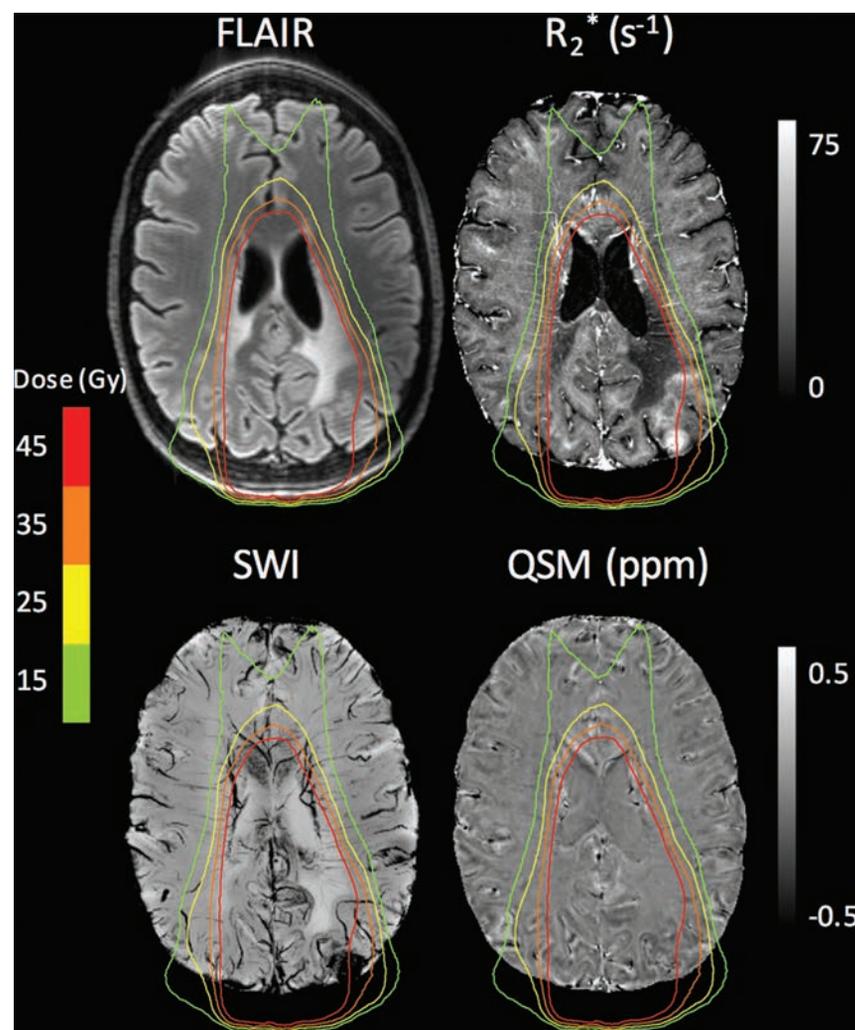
Patient 2 showing white matter abnormalities within the high-dose region as evidenced on FLAIR, R_2^* , and SWI.
